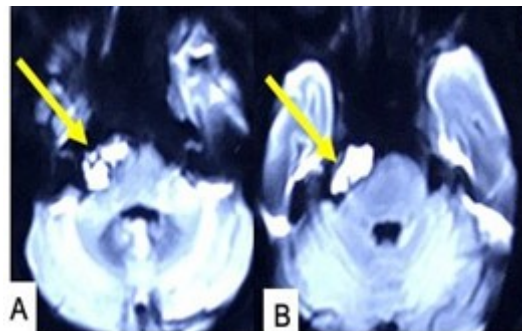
(A,B) MRI of brain axial DW images showing sided small epidermoid in right cerebellopontine angle (arrow marked) causing TN. Source: Figure by authors.
